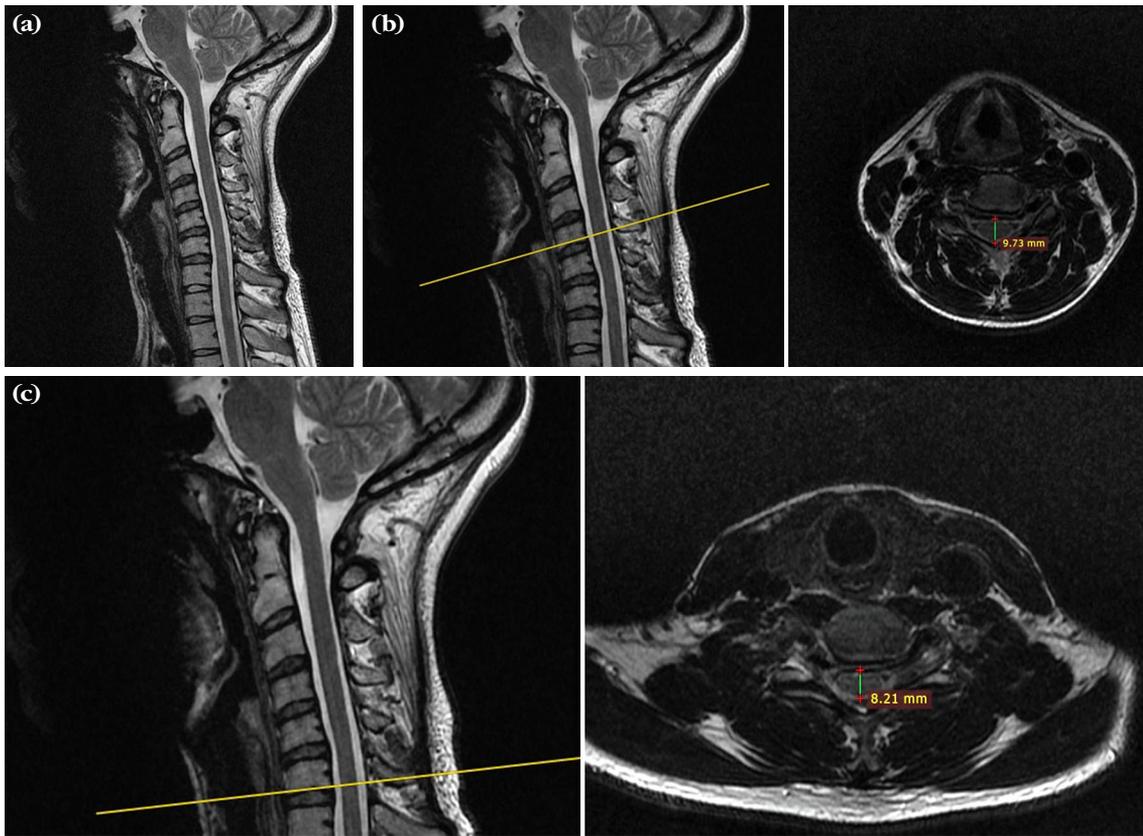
(a) Cervical spine MRI, neutral-position sagittal T2 images, showing minimal cord atrophy at the C6–7 level. (b) Cervical spine MRI, neutral-position sagittal and axial T2 images at the C4 level, demonstrating no abnormality of the spinal cord. The spinal cord diameter measures 9.73 mm. (c) Cervical spine MRI, neutral-position sagittal and axial T2 images, demonstrating minimal cord atrophy at the C6–7 level. The spinal cord diameter measures 8.21 mm. MRI, magnetic resonance imaging.
